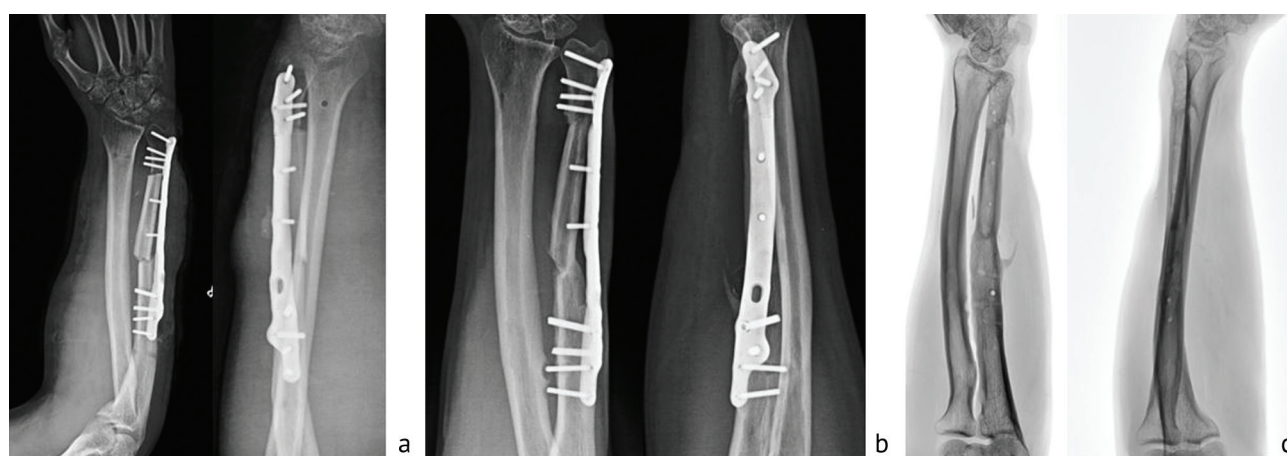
Injured patient A.: *a* radiographs of the forearm after plastic surgery and fixation with a 3D-implant; *b* radiographs of the forearm 6 months after surgery; *c* digital radiographs of the forearm after removal of the metal implant (12 months after reconstructive surgery); *d* function of the upper limbs after rehabilitation
